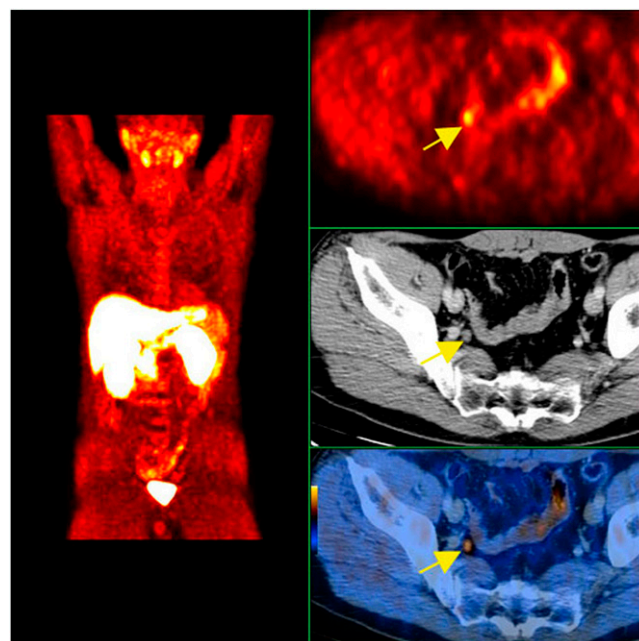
A 60-y-old man with history of prostate cancer who had undergone resection and had rising PSA level. Right column from top to bottom shows ^{18}F -fluorocholine PET, pelvis CT, and fused PET/CT images demonstrating abnormal accumulation of radiotracer in normal-sized right internal iliac lymph node (arrows). Maximum-intensity-projection image on left shows normal biodistribution of ^{18}F -fluorocholine and no other suggestive lesions. (Courtesy of Mohsen Beheshti, St. Vincent's Hospital, Linz, Austria.)
